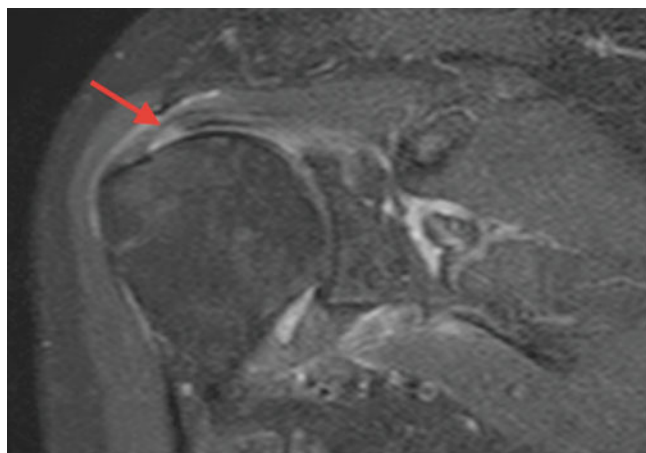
MRI image in coronal STIR showing an Ellman II degree lesion on the articular side of the supraspinatus tendon (red arrow)
